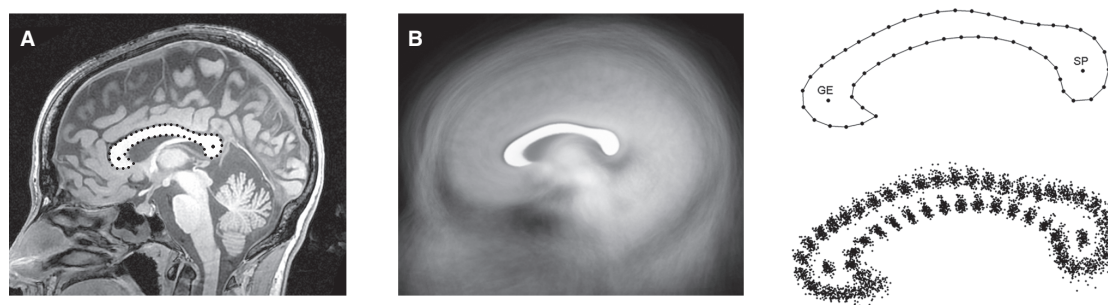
The morphology of the corpus callosum was modeled by using the center of the genu, the center of the splenium, and 50 equally spaced semi-landmarks along the outline. Data were sampled on midsagittal magnetic resonance imaging section (A). The coordinates from 102 young adults were superimposed by Procrustes registration, by sliding the semi-landmarks according to a criterion of minimum bending energy (B). The superimposed image shows the corpus callosum mean shape computed as geometrical average of the whole sample.
